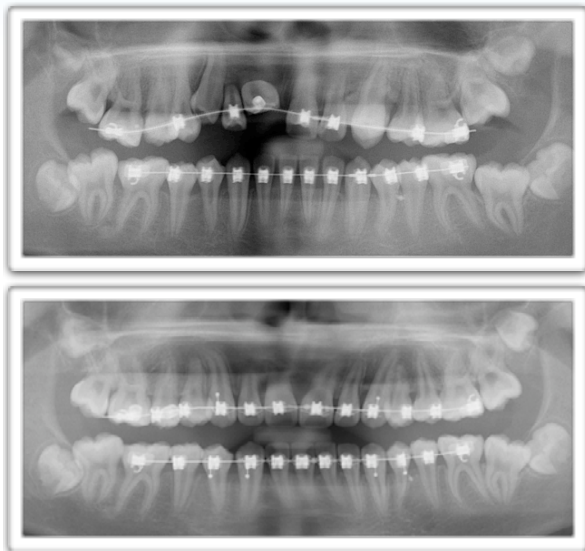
Comparison between radiographs in 13th and 24th month.
